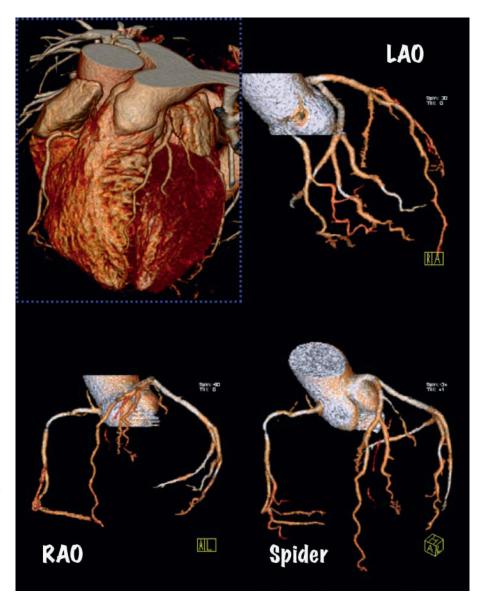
Volume rendering is helpful in cardiac CTA datasets to display the anatomy of coronary arteries. After semi-automated segmentation of the coronary arteries out of the entire scan volume, standard-viewing projections may be created such as the LAO, RAO and spider view
